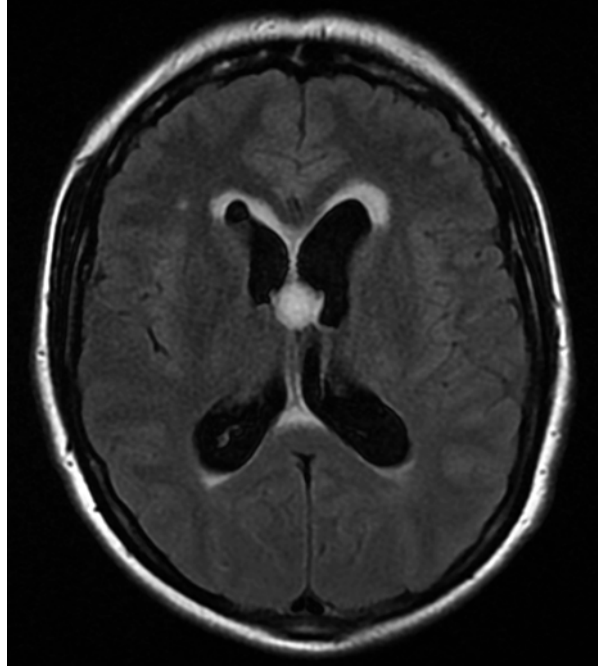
T2-weighted axial image of a patient with a colloid cyst of the third ventricle
